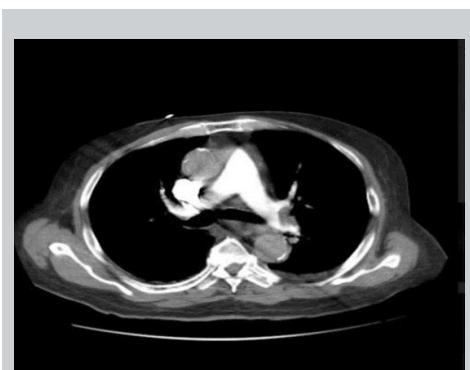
CT pulmonary angiogram showed left side pulmonary embolism.
